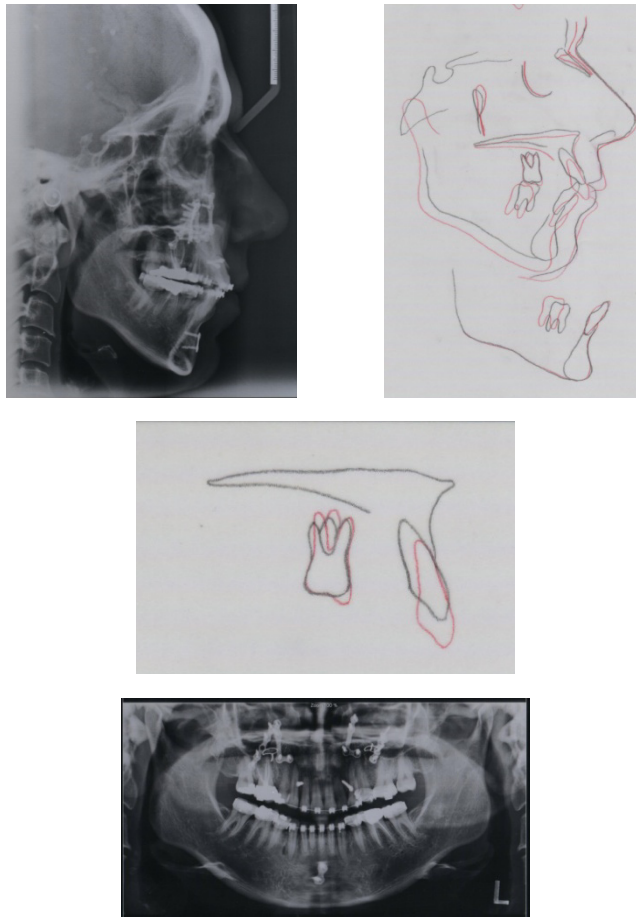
Figs 17-a to 17-d. post treatment cephalogram, superimposition of pretreatment (red) and post treatment (black) cephalometric tracings and panoramic radiograph.
